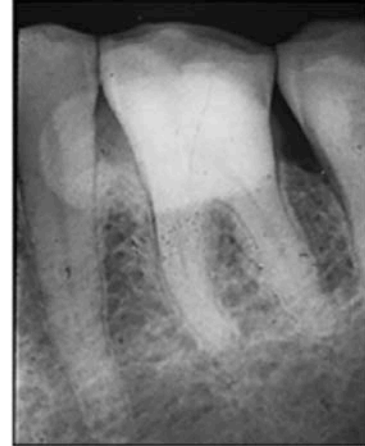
Periapical radiographs demonstrating erosion.
